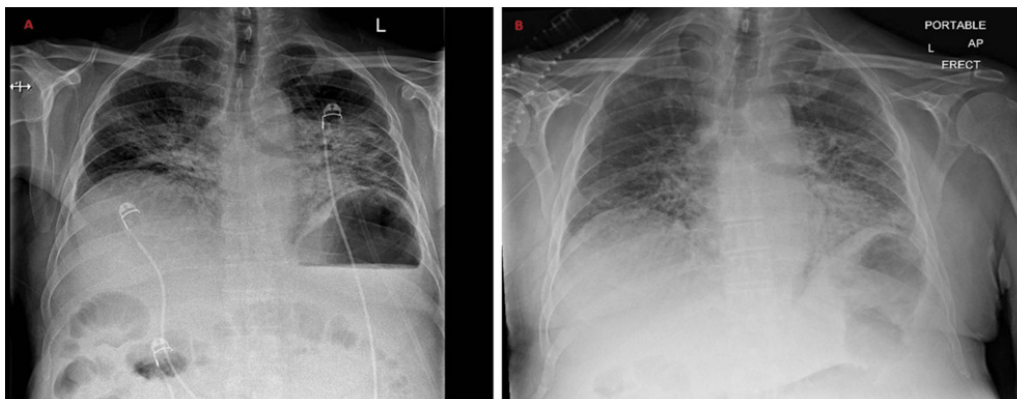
Serial chest radiographs demonstrating progression of pulmonary changes. (A) Admission chest radiograph showing bilateral mid-to-lower zone airspace opacification, more pronounced on the left, in keeping with early pneumonitic change or pulmonary oedema. (B) Repeat chest radiograph on Day 6 demonstrating persistent and relatively unchanged florid bilateral mid-to-lower zone consolidation with no pleural effusion, consistent with evolving severe pneumonitis.
